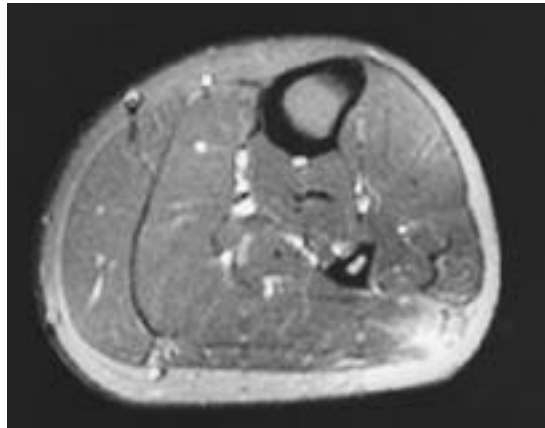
T2-weighted MR image demonstrates ill-defined high attenuated lesion in posterolateral aspect of upper calf region.
